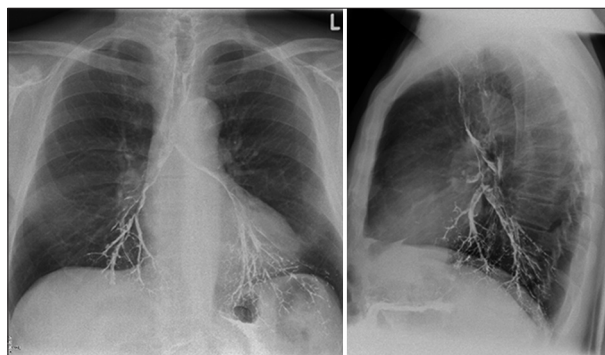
Chest x-ray. The film showed aspiration of swallowed barium in both the right and left main stem bronchi. The barium also spread into the smaller airways, producing a tree-in-bud appearance
